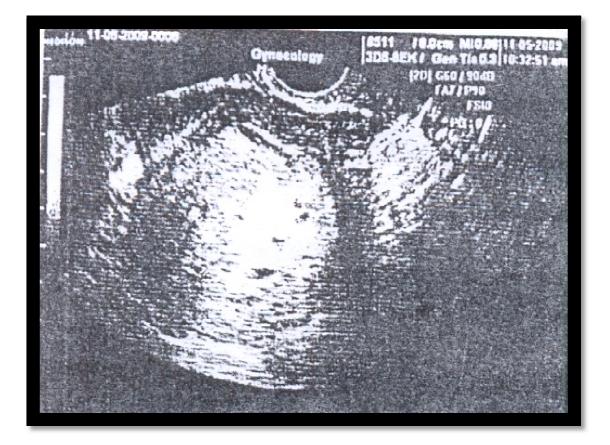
A 31 years old patient who was pregnant \pm 9 weeks, presenting by severe vaginal bleeding. Ultrasound showed endometrial thickness of 35 mm suggestive of RPOC as a result of incomplete spontaneous abortion.
